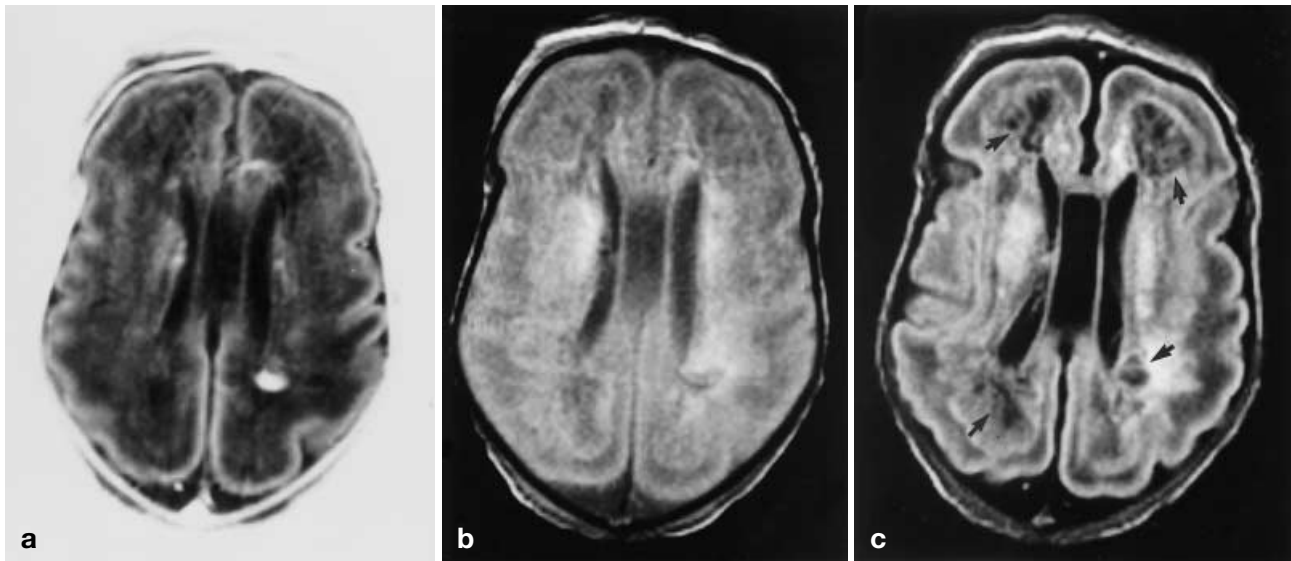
a Axial IR, b Proton-density-weighted, and c FLAIR MR images in a neonate born at 31 weeks, with a postconceptional age of 33 weeks (case 17) show multiple SI changes throughout the periventricular white matter and a single high SI lesion in the left parietal region on all sequences; the latter is consistent with a focal hemorrhage. The IR and proton-density-weighted images show bilateral frontal and parietal precystic lesions with a SI almost identical to cerebrospinal fluid (CSF). These lesions are much better demarcated with FLAIR image and have an SI identical to CSF, consistent with cysts (arrows in c)
